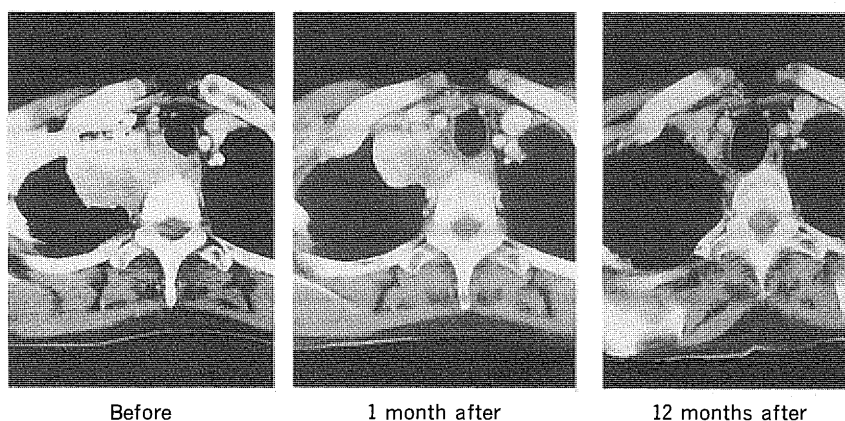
Contrast-enhanced CT scan of a case of mediastinal lymph node metastasis from clear cell carcinoma of the ovary depicting a heterogeneous irregular enhanced tumor with tracheal compression and involvement of adjacent vessels before treatment. The tumor disappeared 12 months after thermo-chemo-radiotherapy.
